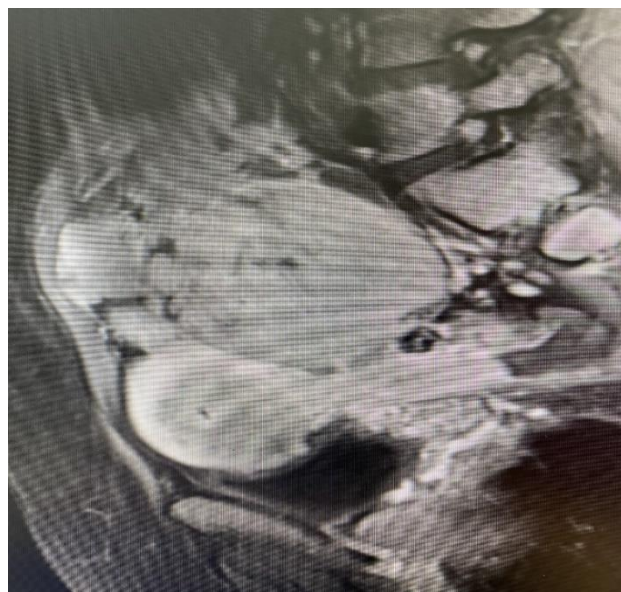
Magnetic resonance image of the uterus and right adnexa
